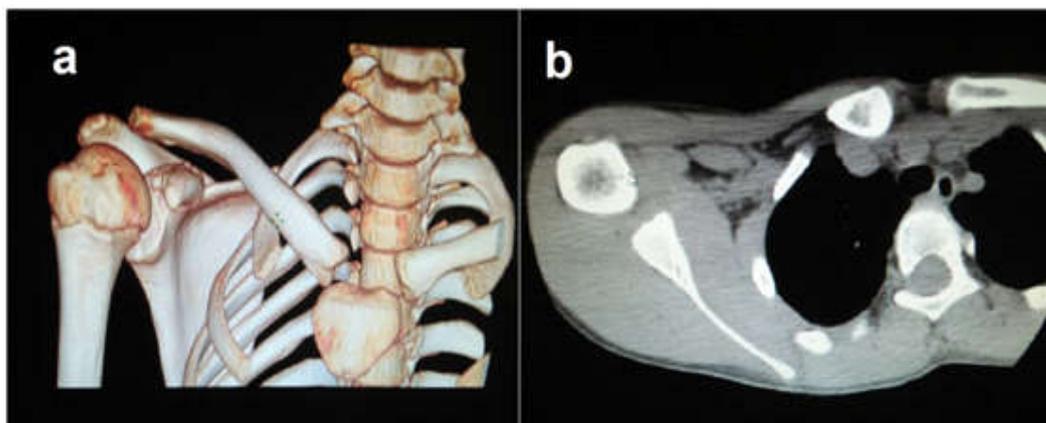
control by CT objectifying the spontaneous regression of the lesion.
